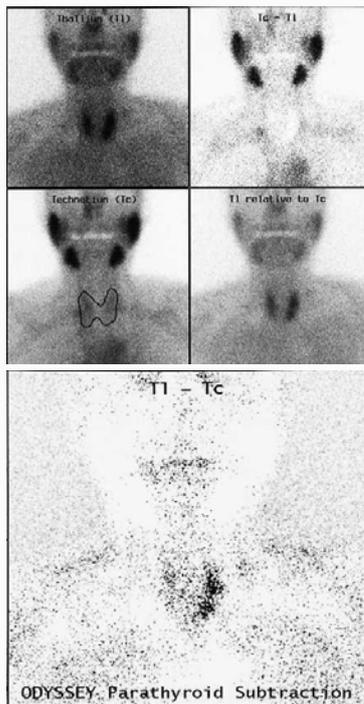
The Tl-Tc subtraction scintigraphic findings indicated Tl uptake in the upper and lower dorsal side of the left lobe.
